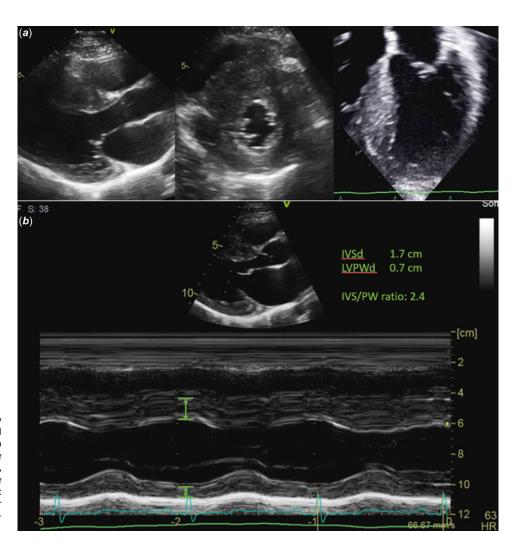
a*) Asymmetric septal hypertrophy shown on transthoracic two-dimensional echocardiogram images of a teenager with hypertrophic cardiomyopathy. Views include parasternal long axis (left), short axis (middle), and apical four chamber (right). *b*) M-mode measurement of the end-diastolic septal and left ventricular posterior wall thickness in a teenager with hypertrophic cardiomyopathy with asymmetric septal hypertrophy.
